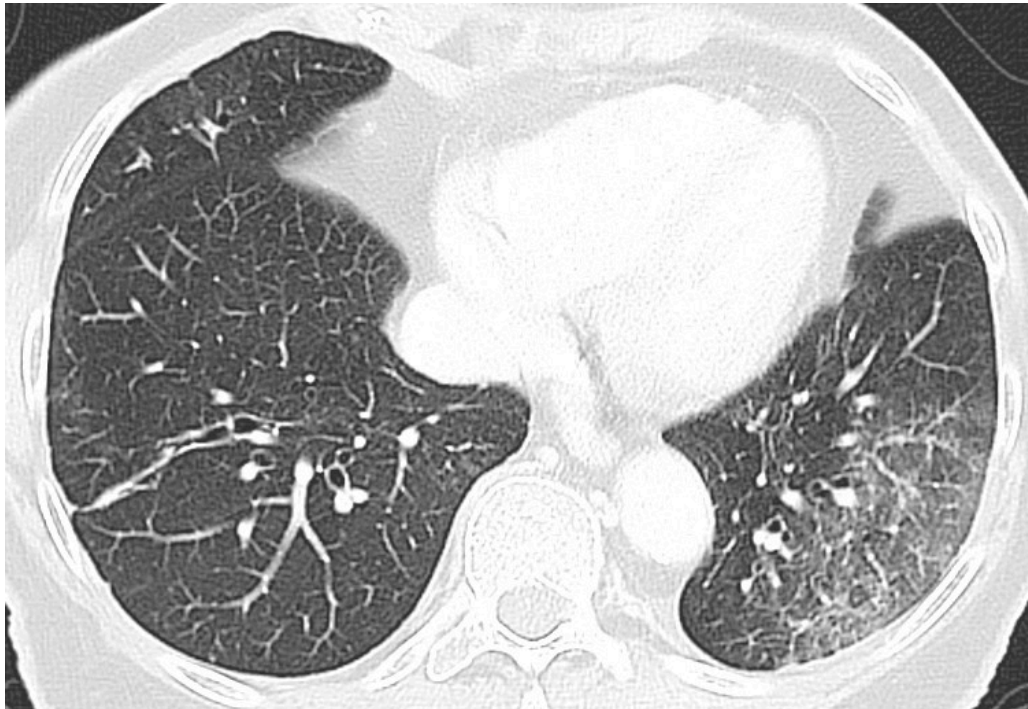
Patient with COVID-19 with reduced general condition, nausea, vomiting, syncope and possible chills. CT thorax two days after symptom onset shows ground-glass opacities most distinctly in the left lower lobe.
